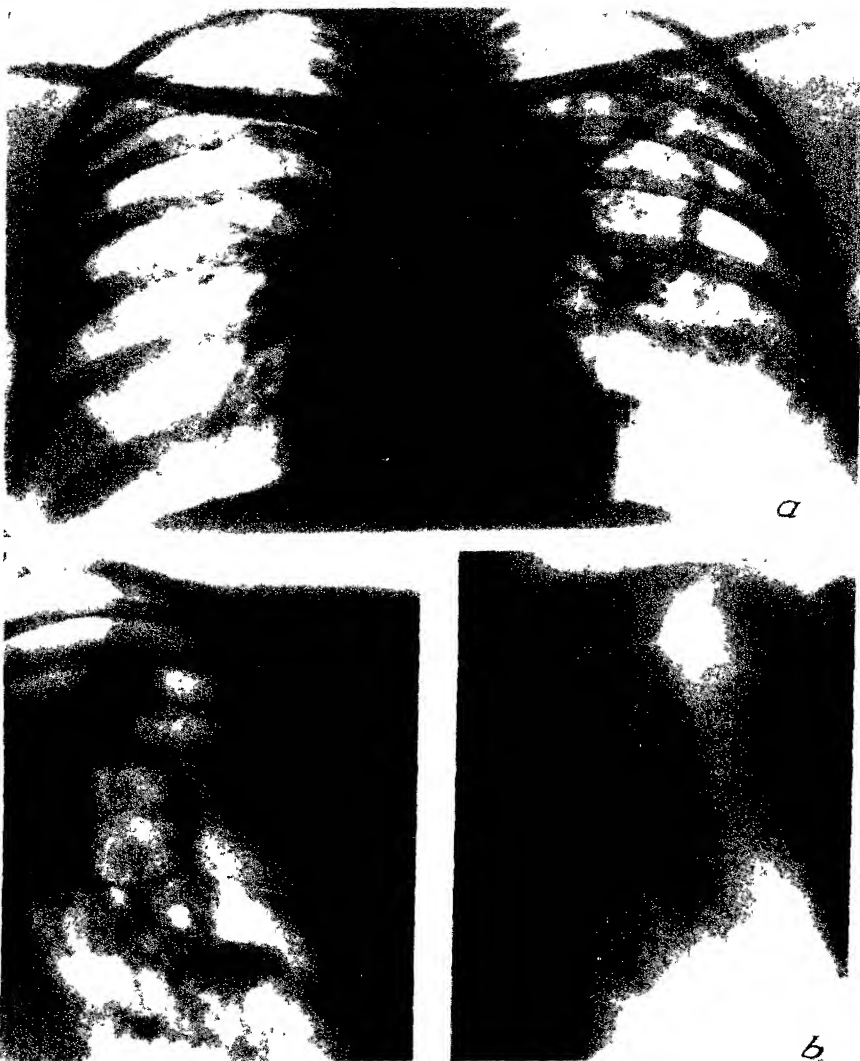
X-rays of patient M
